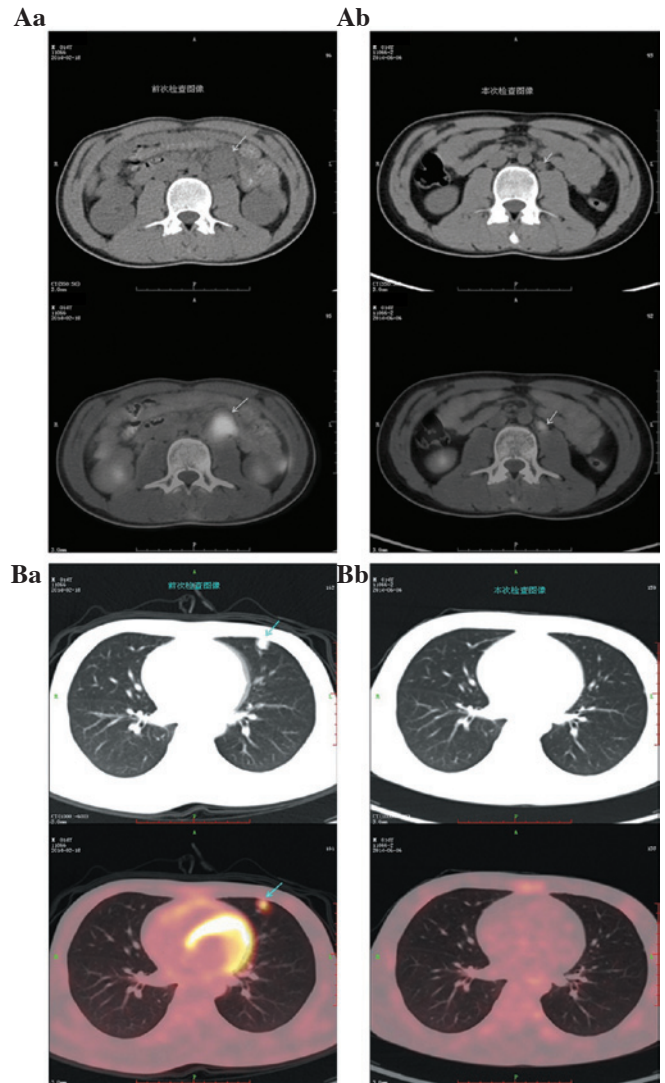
Positron emission tomography/computed tomography scans demonstrating complete remission of the pulmonary lesion and partial remission of the retroperitoneal lesion in response to chemotherapy. (Aa) Arrows indicate retroperitoneal lymphodorus metastasis in pre-chemotherapy. (Ab) Arrows indicate retroperitoneal lymphodorus metastasis in post-chemotherapy. (Ba) Arrows indicate the pulmonary lesion in pre-chemotherapy. (Bb) Post-chemotherapy in the pulmonary lesion.
